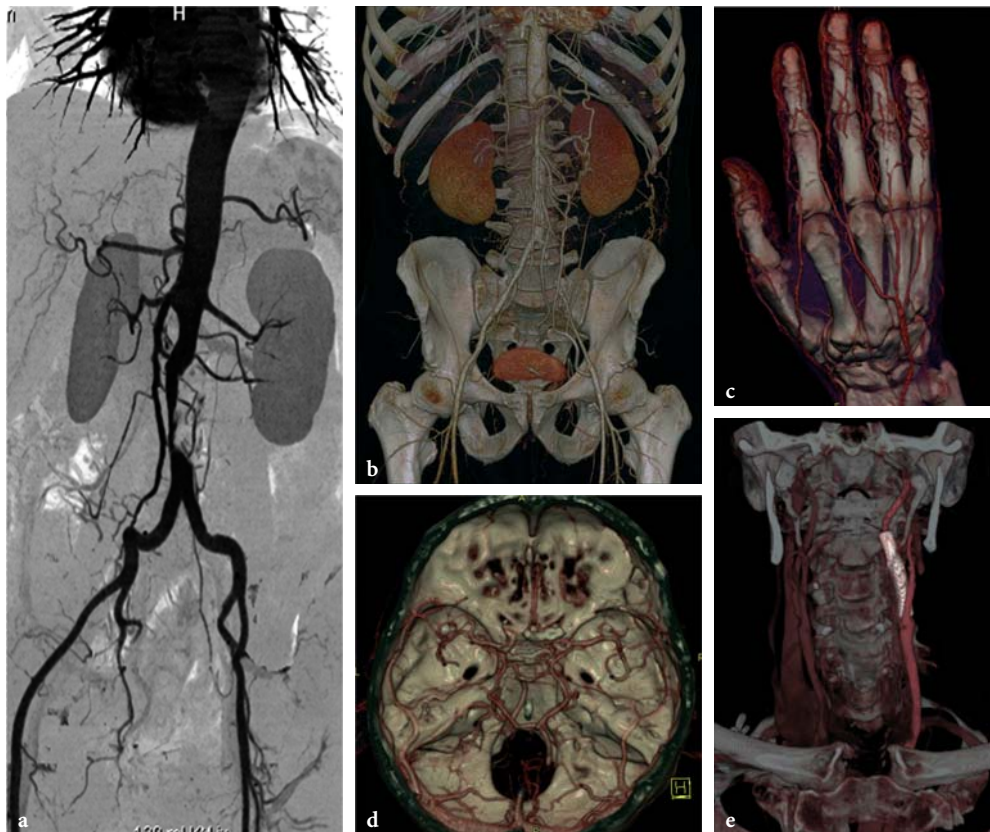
Case examples of 16-slice CT angiography examinations using a CT scanner with 16×0.75 -mm collimation. High-resolution CT angiography of the aorta and iliac arteries with a 1200-mm scan range, visualized in an angiographic-type maximum intensity projections (MIP) display (a) and volume-rendering technique (b). CT angiography examinations of the digital arteries (c), the carotid arteries with an inserted stent (d), and the cerebral vessels (e). (Case courtesy of a, b the University of Tübingen, Germany, and c–e the University of Munich, Grosshadern Clinic, Germany)
